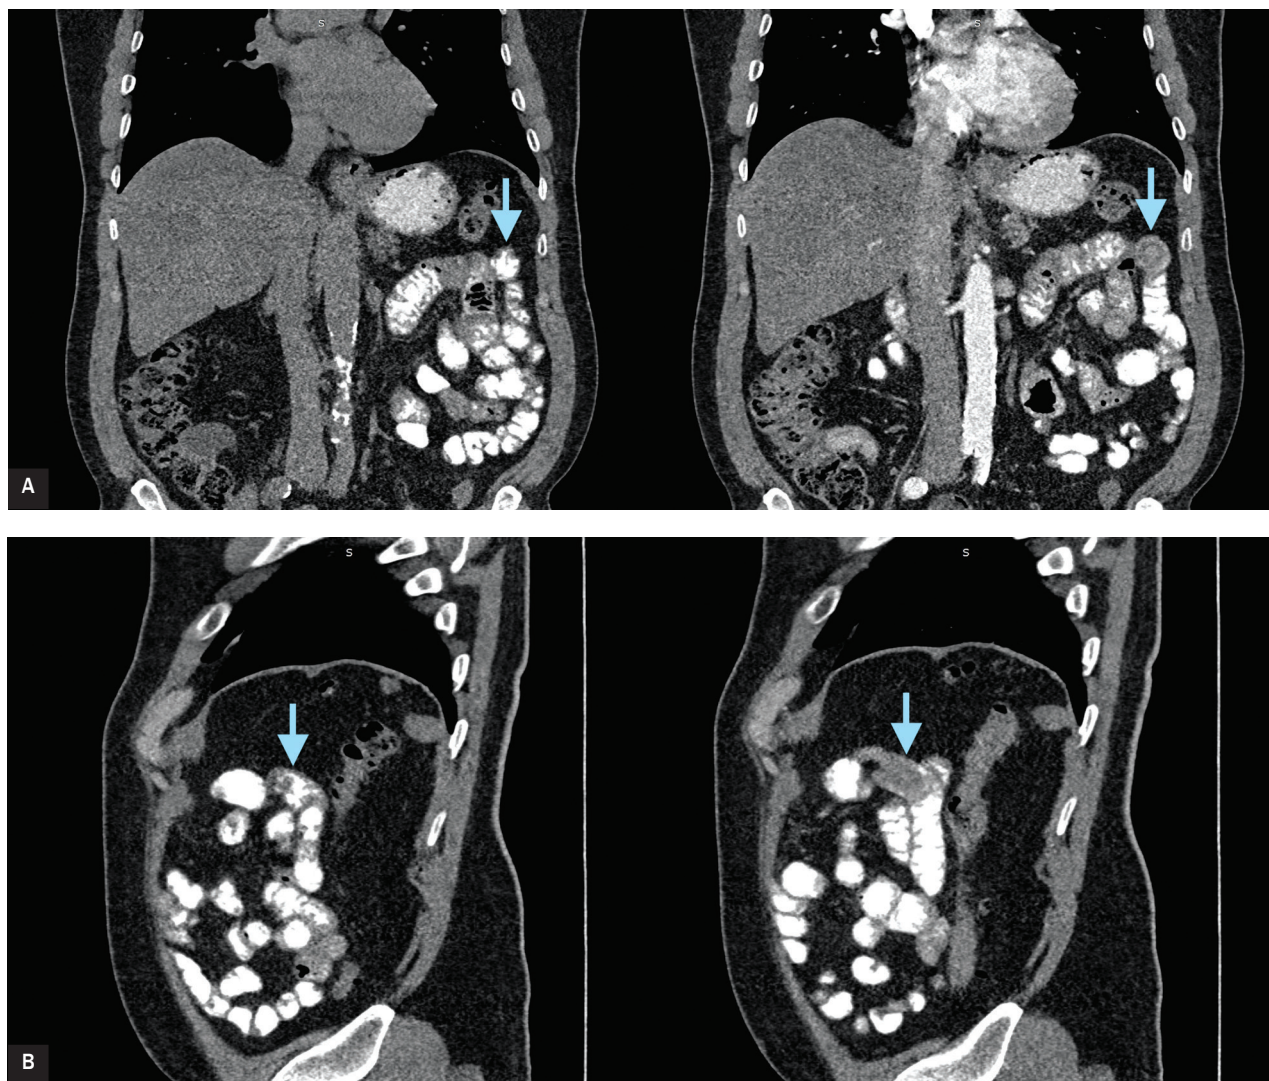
Computed tomography images showing normal small bowel (A1, B1) and a small bowel intussusception on the arterial phase following the intravenous contrast administration (A2, B2) in coronal (A) and transverse (B) projections
